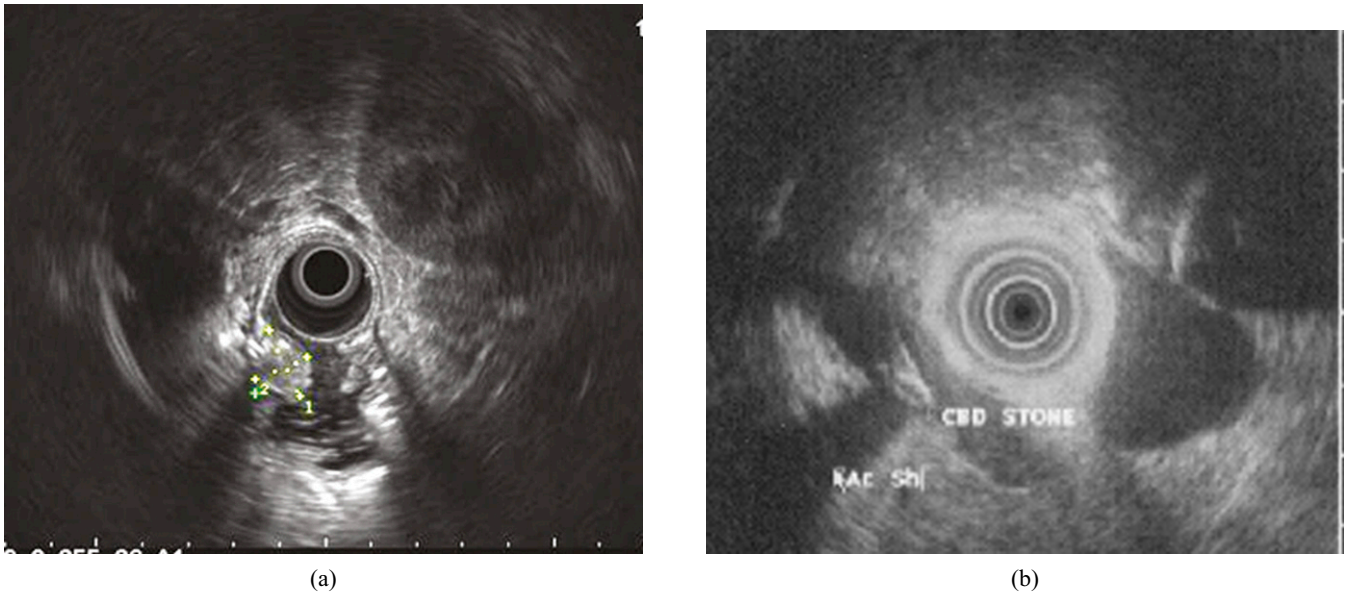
Two different patients with jaundice and no definitive diagnosis on cross-sectional imaging with CT. Image (a) shows a polypoidal lesion within the ampulla consistent with a biopsy-proven adenoma (courtesy of Dr J Ramesh, consultant gastroenterologist, University Hospital of South Manchester NHS Foundation Trust). Image (b) demonstrates a small distal common bile duct stone with characteristic posterior acoustic enhancement (courtesy of Dr VY Kaushik, consultant gastroenterologist, Royal Blackburn Hospital).
